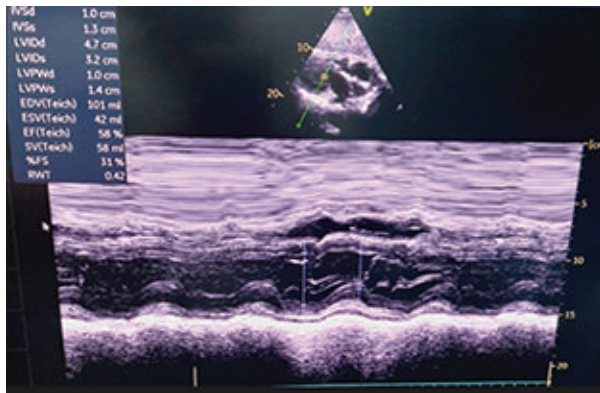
Postoperative Echocardiography show minimum Pericardial Effusion.
